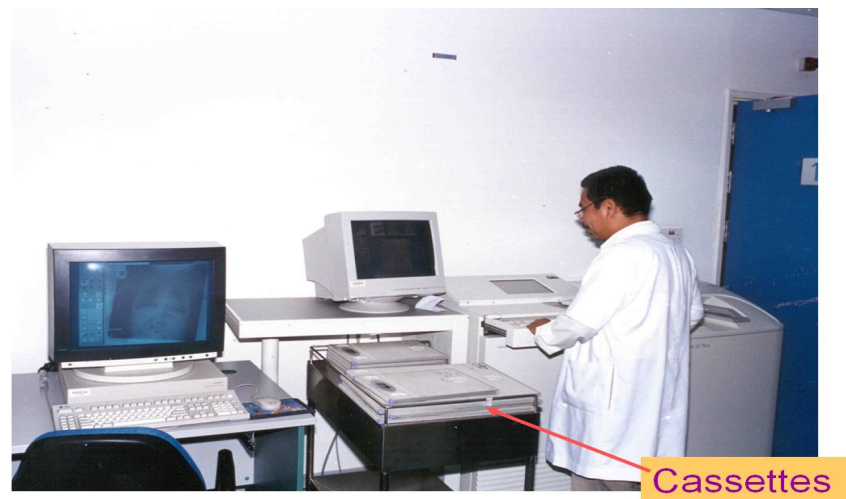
Figure A-3: Computed Radiography
